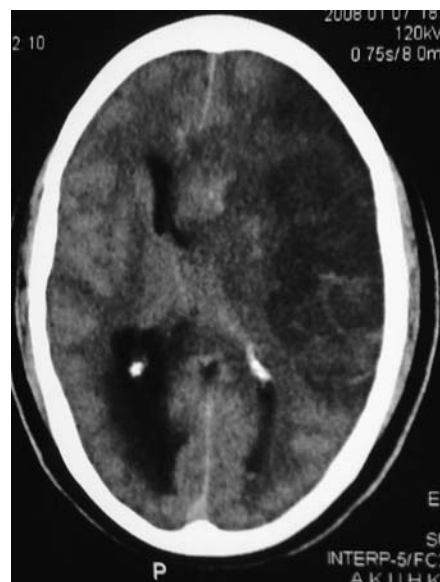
CT Brain showing large right MCA territory infarct with significant midline shift and mass effect.
